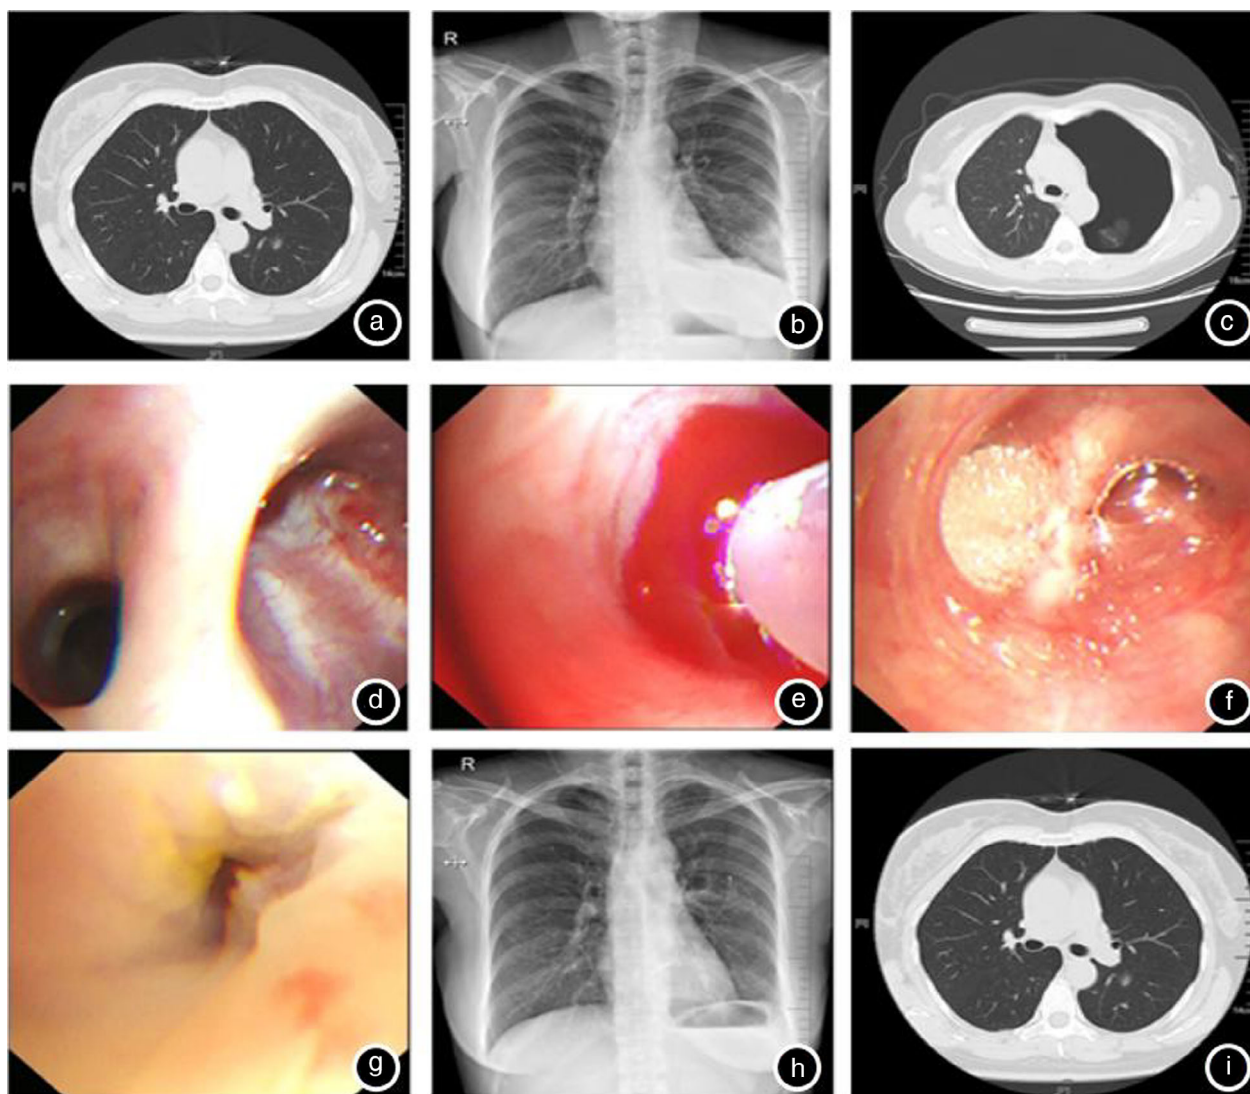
(a) Preoperative chest CT showed a small nodule in the dorsal segment of the left lower lung. (b) Chest radiography showed a small amount of pneumothorax 21 days after surgery. (c) Chest CT showed left hydropneumothorax, 90% compression of the left lung, and subcutaneous emphysema of the left chest wall more than one month after surgery. (d) Bronchoscopy showed fistula formation in the B6a subsegment of the dorsal segment of the left lower lobe. (e, f) Autologous blood, and absorbable gelatin sponge closure of the fistula. (g) Bronchoscopy showed that the fistula was significantly reduced after using the cytobrush combined with autologous blood and gelatin sponge closure. (h, i) Chest radiography and chest CT after the pneumothorax was resolved.
